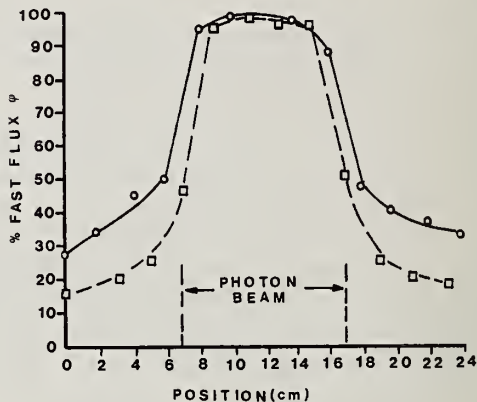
Percent fast neutron flux versus position for  $10 \times 10 \text{ cm}$  45 MV X-ray beam based on phosphorus activation (  $\circ$  = in plane of electron orbit,  $\square$  = perpendicular to electron orbit).
